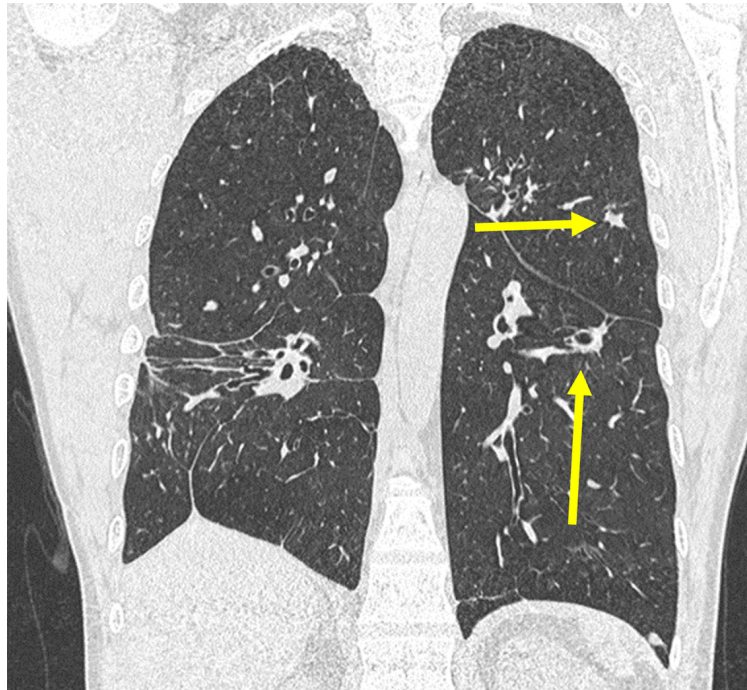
Coronal CT scan image of the chest in lung window one year after the start of anthelmintic treatment, showing a significant reduction in the size of pulmonary nodules, leaving bronchiectasis in the left lower lobe as sequela.
